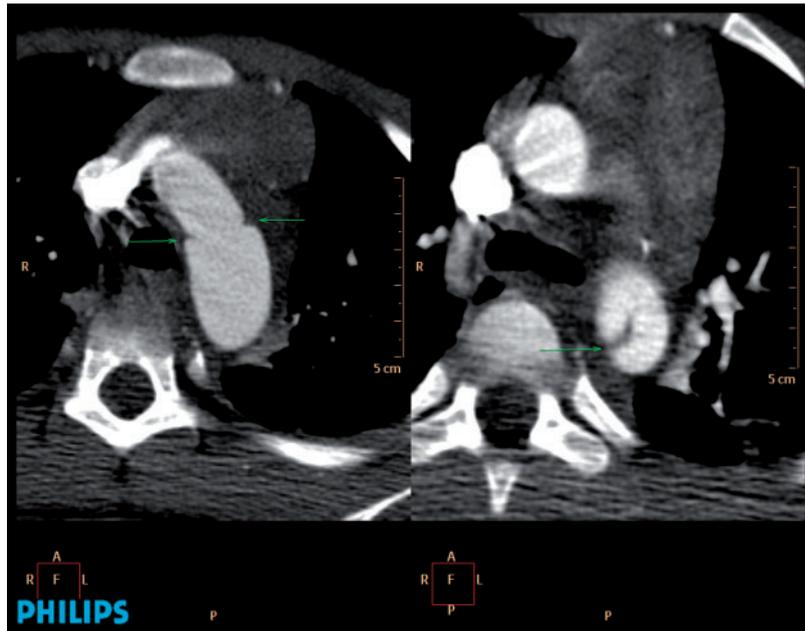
Chest CT scan showing (a) a 3-cm long aortic injury at the level of the ligamentum arteriosum and (b) the injury in the descending aorta.
